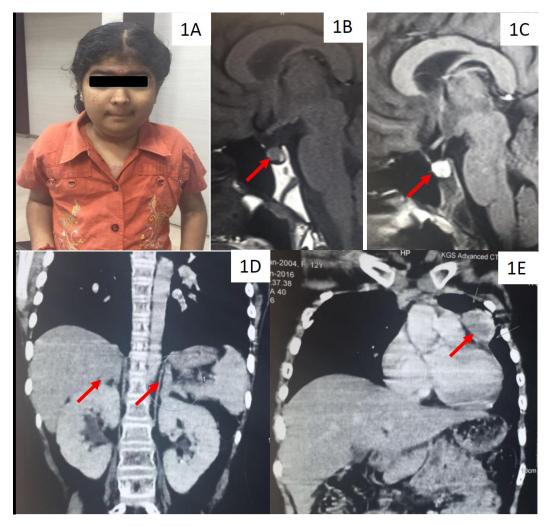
Clinical photograph of the child (fig 1A), MRI of pituitary showing mild pituitary enlargement with convex upper surface (fig 1B) with intense homogenous enhancement (fig 1C), heterogeneously enhancing mixed density lesion with faint calcification noted on left side anterior mediastinum measuring 3.8x 3.5 cm (fig 1D) and diffuse hyperplasia of both adrenal glands (fig 1E).
